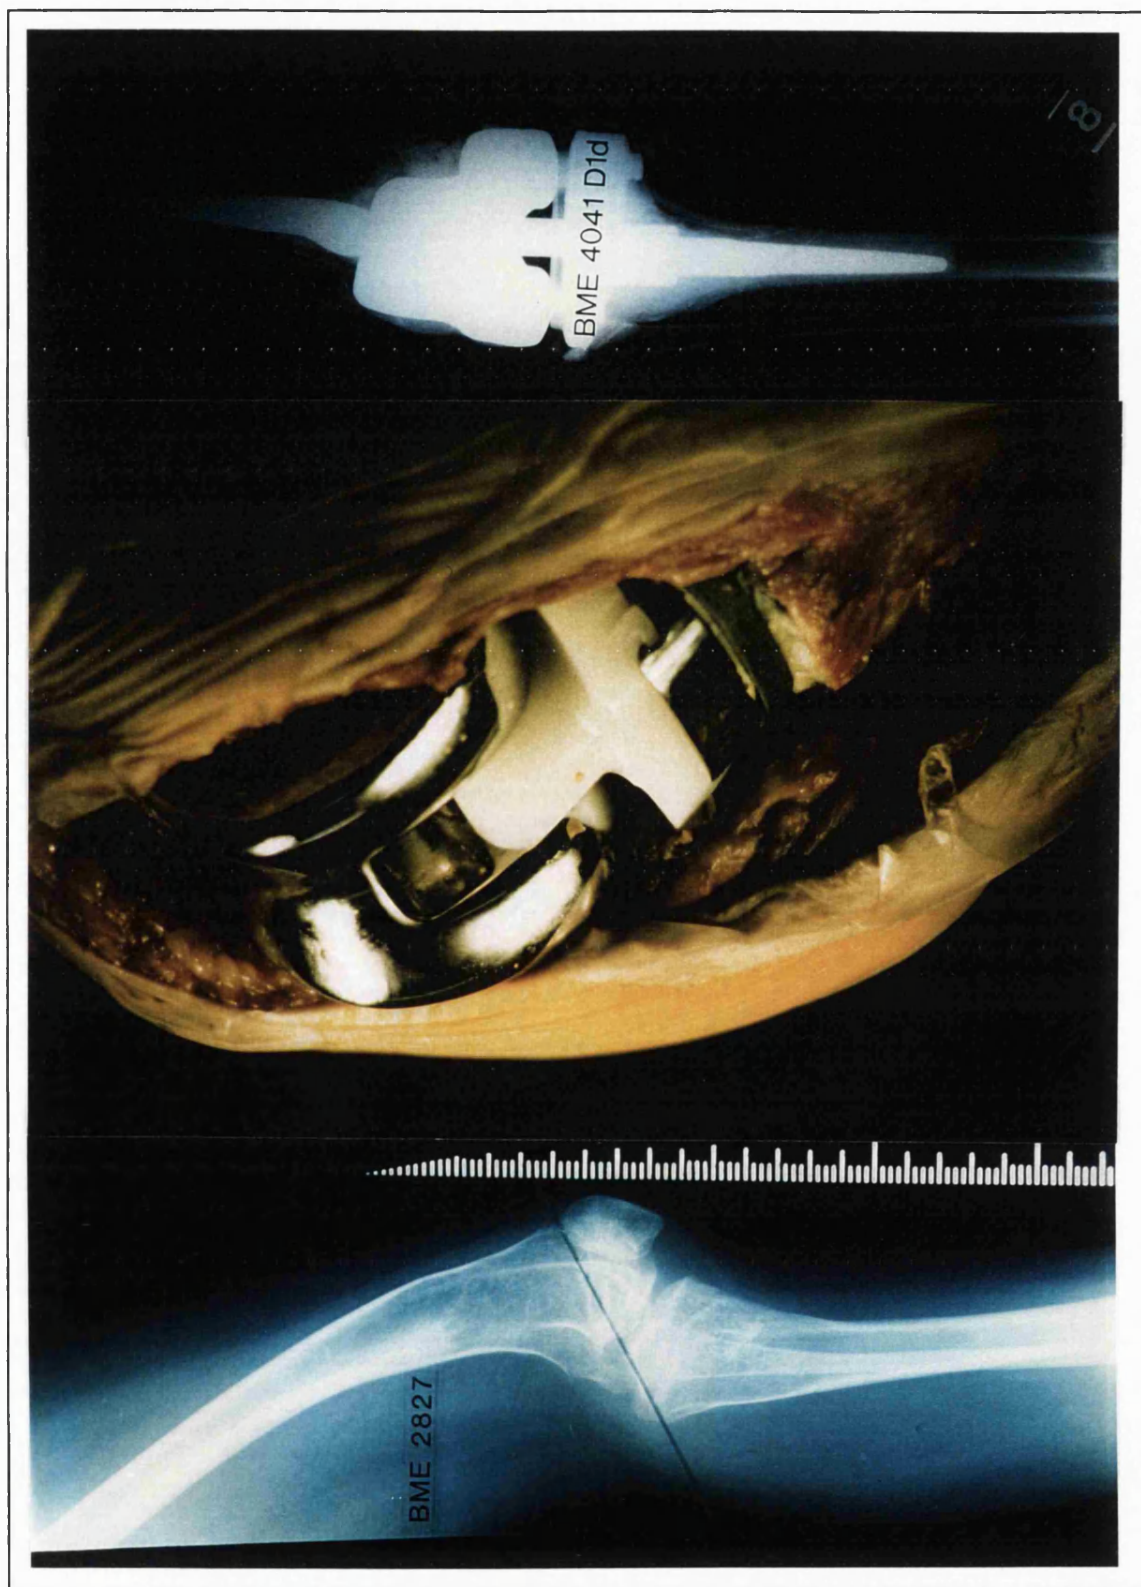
BOTTOM : A patient who requires a customised knee. MIDDLE : A customised knee being implanted. TOP : A post-operative radiograph.
